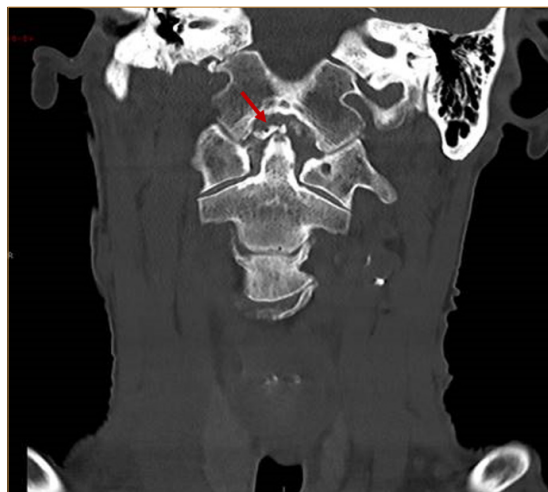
Computed tomography of the cervical spine: coronal view with red arrow showing soft tissue calcification surrounding the odontoid process characteristic of Crowned Dens Syndrome.
